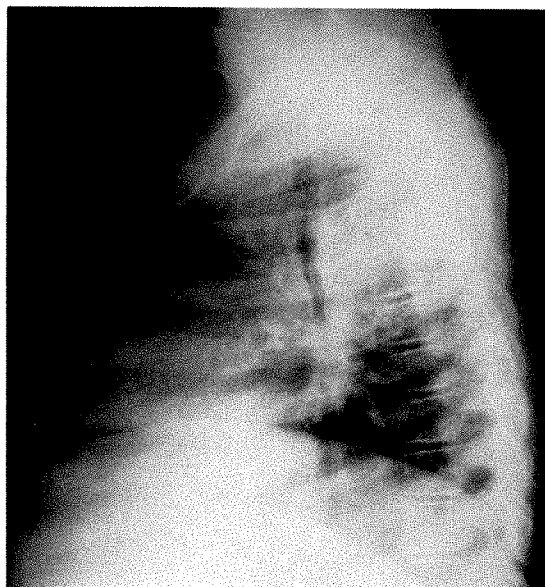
Case IV. In the lateral roentgenogram the mass is seen posteriorly, compressing slightly the wall of the trachea.
